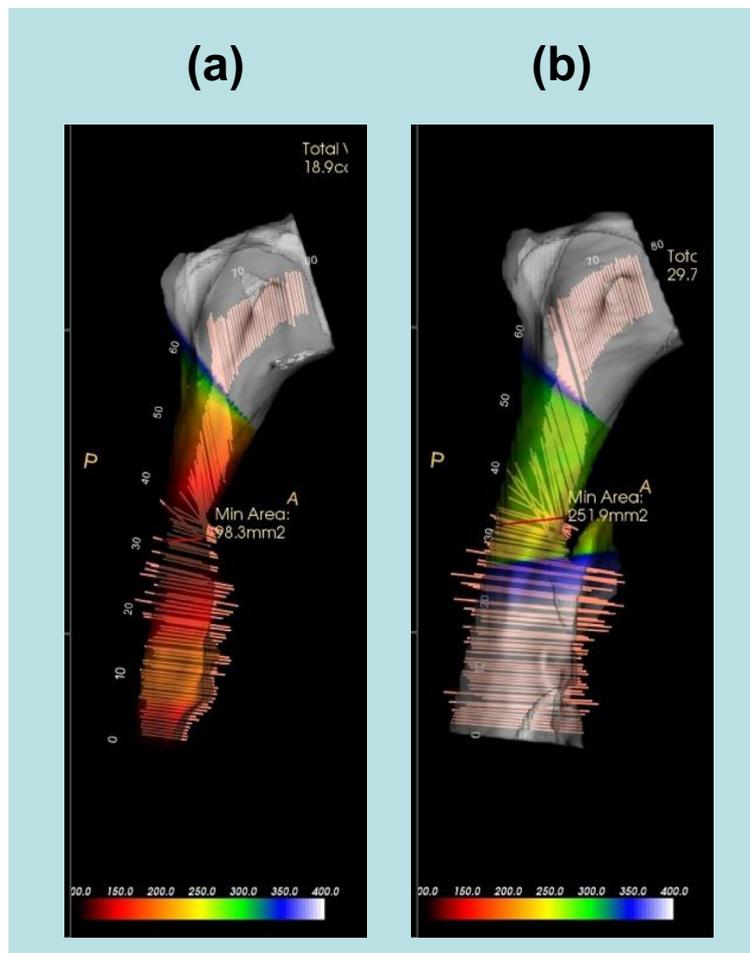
a. Pre-treatment 3D upper airway reconstruction from 3D CBCT scans, showing minimum surface area of 98.3 mm² and upper airway volume of 18.9 cm³. b. Post-treatment 3D upper airway reconstruction from 3D CBCT scans, showing minimum surface area of 251.9 mm² and upper airway volume of 29.7 cm³.
